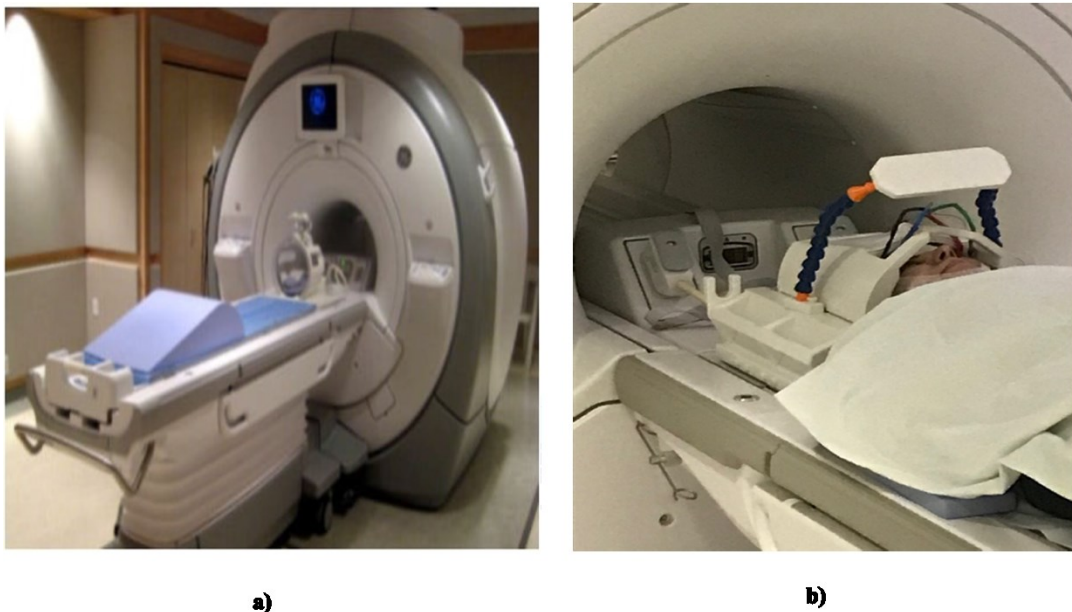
a) The MRI scanner at Perform Centre. b) Our setup inside the scanner.
